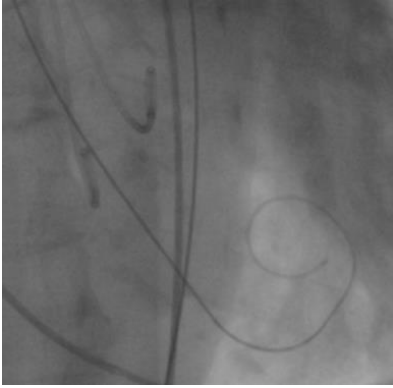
Intraoperative chest x-ray image demonstrating a pre-shaped stiff wire in the left ventricle and two pigtail catheters in the left coronary sinus and in the non-coronary sinus.*
